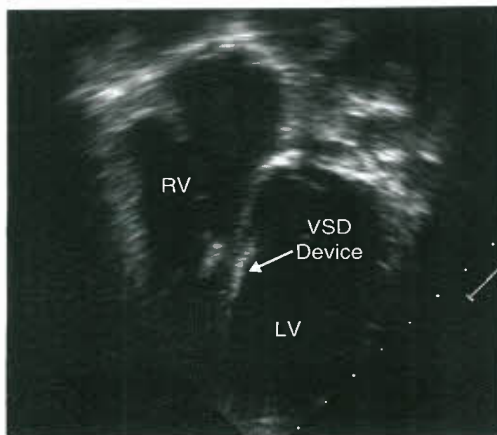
Transesophageal echo four-chamber view demonstrating successful Amplatzer VSD occlusion device deployment across a midmuscular VSD.
